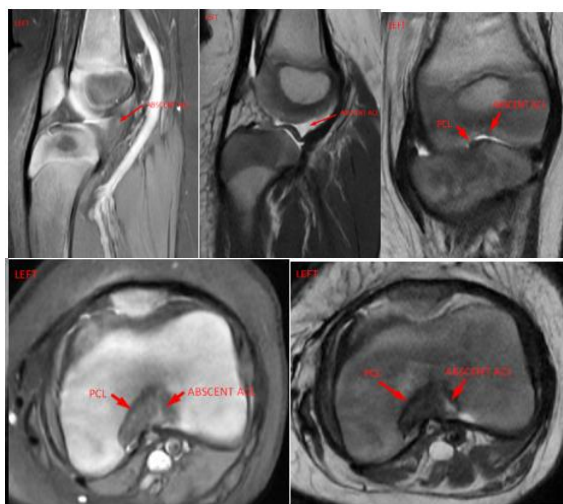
Left Knee MRI in Sagittal Plane with Pdfs/ T2wi, Coronal T2 and Axial Pdfs / T2wi Sequences Shows Absent ACL and Vertically Oriented PCL
